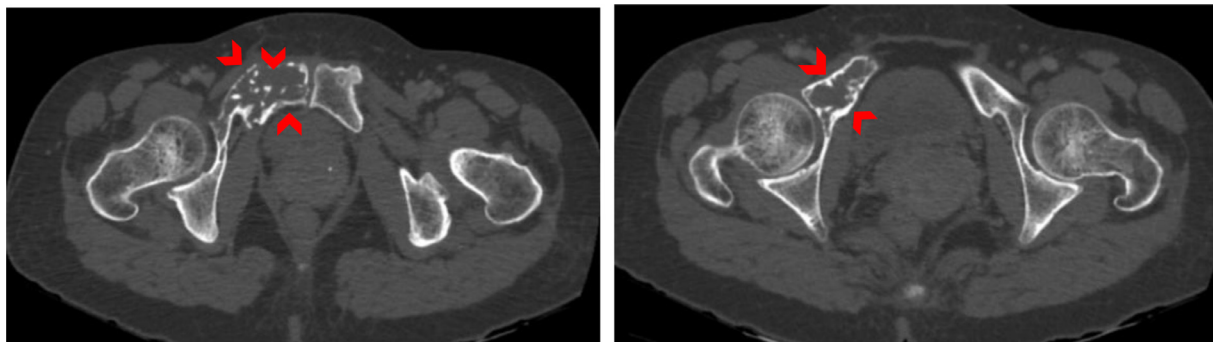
On the CT scan images, lytic bone lesions were observed at the superior and inferior pubic ramus and the anterior surface of the right acetabulum, resulting in cortical disruptions and extension into the adjacent soft tissue (arrowheads).
